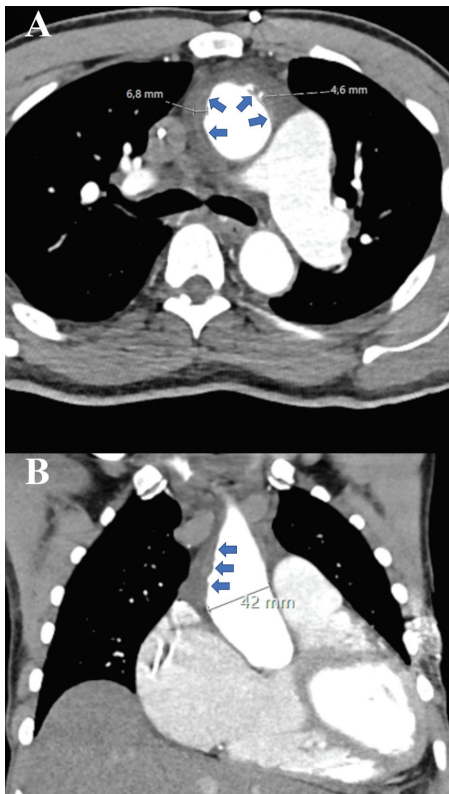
Preoperative computed tomography imaging: Transverse (A) and frontal (B) plane demonstrate the sizes of penetrating aortic ulcers (A: 6.8 mm, 4.6 mm) and soft plaques (B: arrows).
